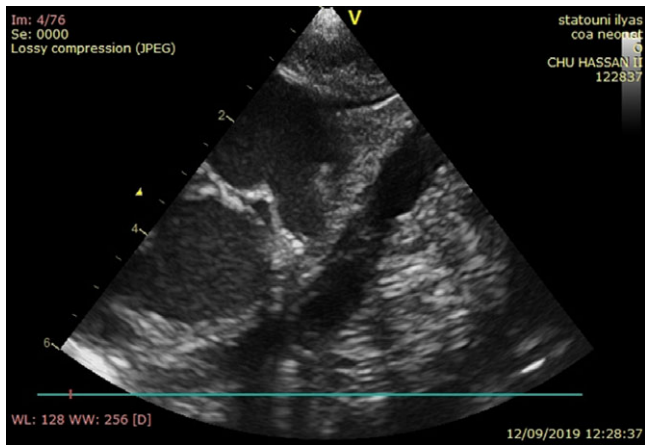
Balloon dilatation and echocardiography after dilatation.
